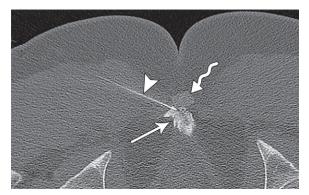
51-year-old man with coccyx pain after a fall onto his low back. Axial CT image shows a posterolateral (transgluteal) approach, with the needle (arrowhead) directed immediately anterior to the coccyx (squiggly arrow) near the sacrococcygeal junction, in the expected location of the ganglion impar. Contrast is used to confirm needle tip location in the precoccygeal soft tissues (straight arrow), without extension beyond the puborectalis sling.
